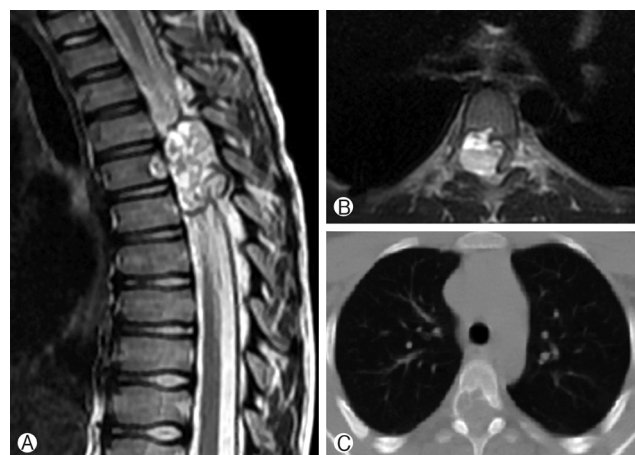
(A, B) Cyst extending to spinal canal with a press on medulla is observed on T2 images with non contrast MRI. The cyst is hyperechoic and prominent soft tissue extending is not seen. (C) On non contrast CT images, lytic-destructive expansile mass is observed on T corpus.
